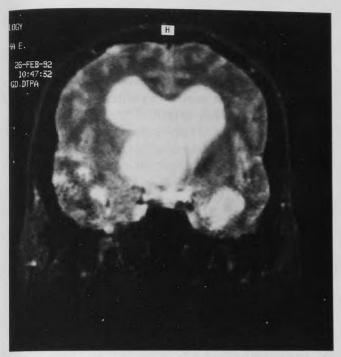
Coronal magnetic resonance imaging reveals a right frontal horn cyst with associated frontal horn expansion.
